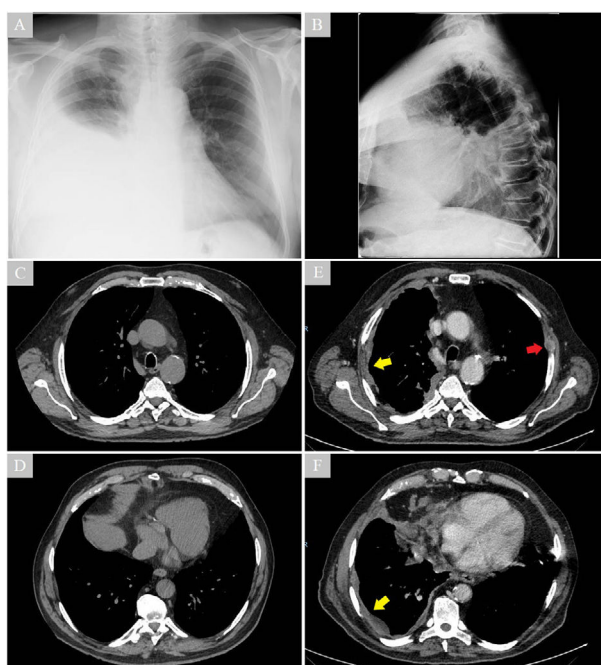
The images show the evolution of the radiological findings over six months. CT scan performed six months prior to admission, with no findings (C and D). Chest X-ray with a right pleural effusion performed when the patient consulted the emergency department (A and B). Diffuse right pleural thickening (yellow arrows) and lytic lesion in the left fourth costal arch (red arrow) after drainage of the pleural effusion (E and F).
